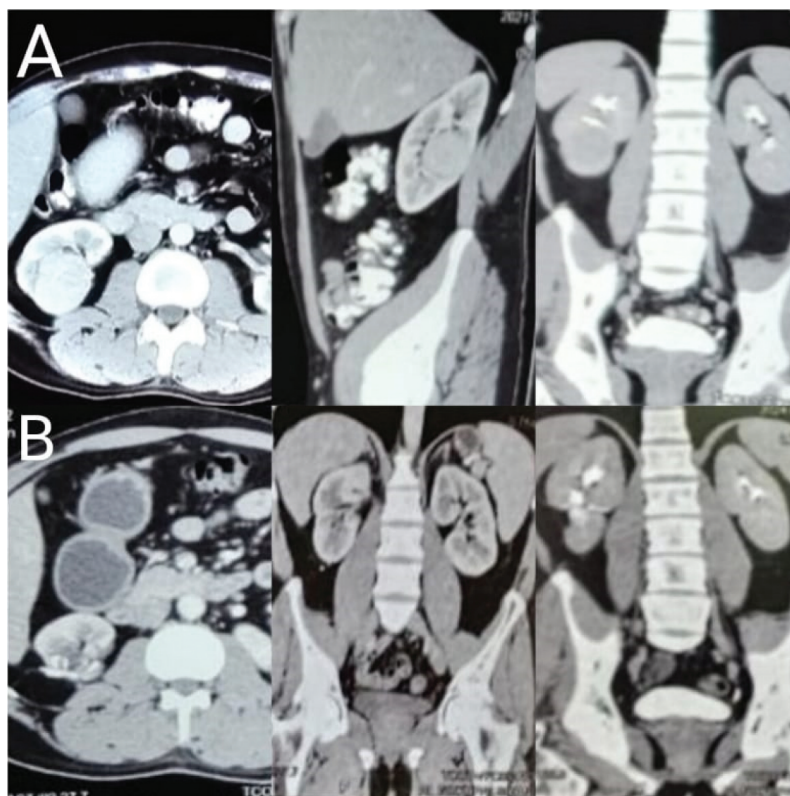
CT images of a patient who needed DJ stent insertion due prolonged urine leakage after RAPN. A: Preoperative images showing a posterior tumor which was more than 50% endophytic. B: Postoperative images after the DJ removal with free tumor bed & no extravasation of IV contrast.
